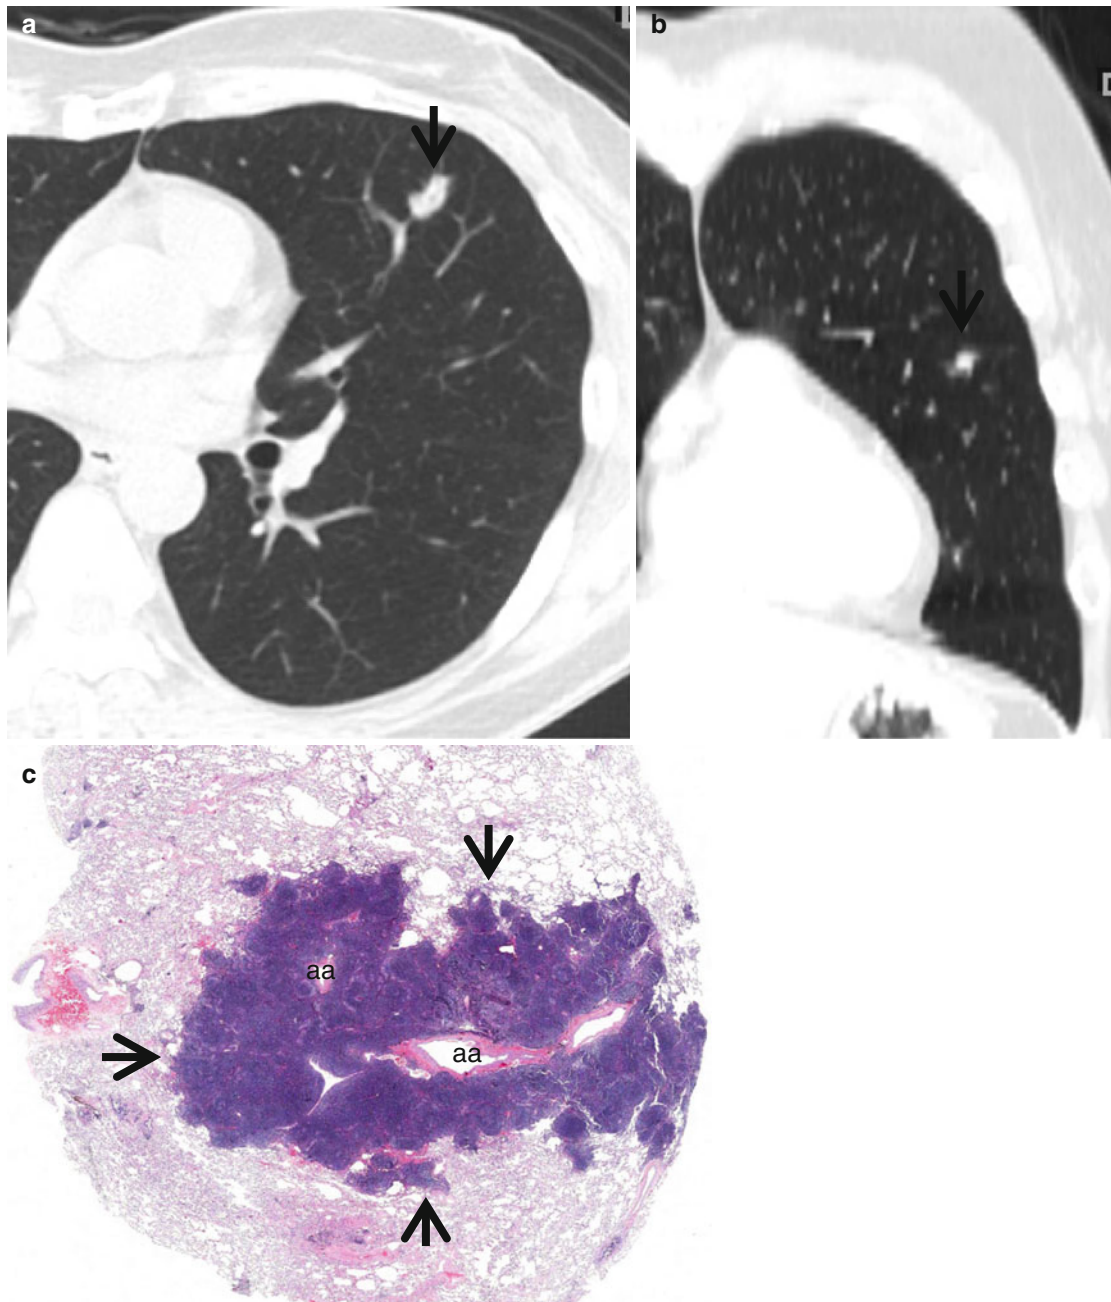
Bronchus-associated lymphoid tissue (BALT) lymphoma in a 51-year-old woman. (a, b) Transverse (a, 2.5-mm section thickness) and coronal reformatted (b) CT scans, respectively, show a 13-mm-sized polygonal nodule (arrows) in lingular division of the left upper lobe. Lesion has internal CT air-bronchogram sign. (c) Low-magnification
